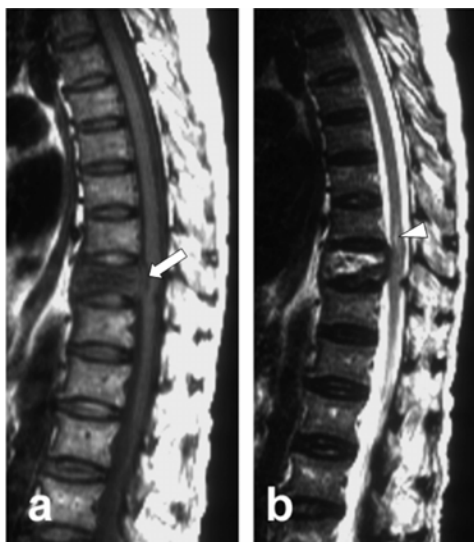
Atypical findings of tuberculosis spondylitis of T7, (a, b) Magnetic resonance image of the thoracic spine in a 69-year-old woman presented with back pain and paraplegia (a) precontrast T1-weighted in sagittal plane (b) T2-weighted in sagittal plane show signal change of bone marrow edema of T7 vertebral body with minimal decrease vertebral body height, convex of posterior border of vertebral body cause central canal stenosis and mild cord compression are noted (white arrow), high signal of the spinal cord, just superior to the infected vertebral is detected (white arrow head), note preservation of the adjacent intervertebral disc, these findings may difficult to differentiate with the neoplasm process
